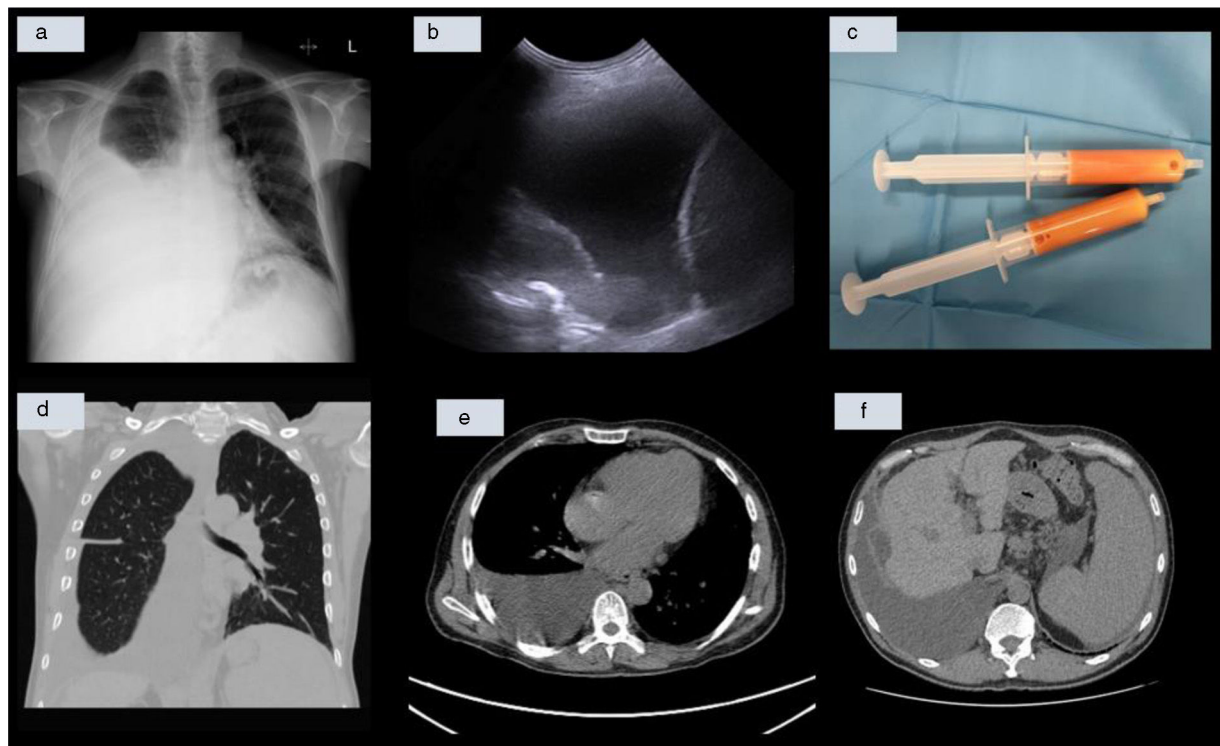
(a) Chest X-rays showing right pleural effusion; (b) chest ultrasound revealing anechoic pleural effusion; (c) milky-appearing pleural fluid; (d and e) chest CT scan with pleural effusion with no lung parenchymal involvement; no other anomalies were detected; (f) abdominal computed tomography scan with splenomegaly and ascites.
